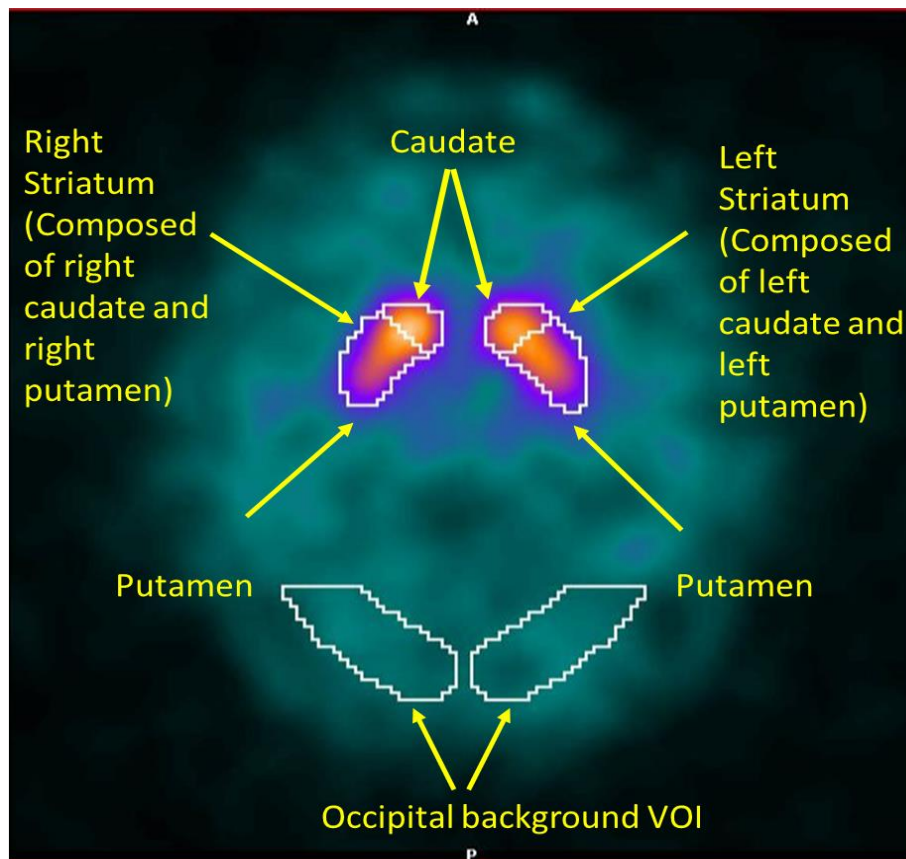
2 DaTQUANT VOIs imposed on a  $^{123}\text{I}$ -FP-CIT SPECT image. The VOI displayed are the caudate, putamen, entire striatum and occipital lobe.
